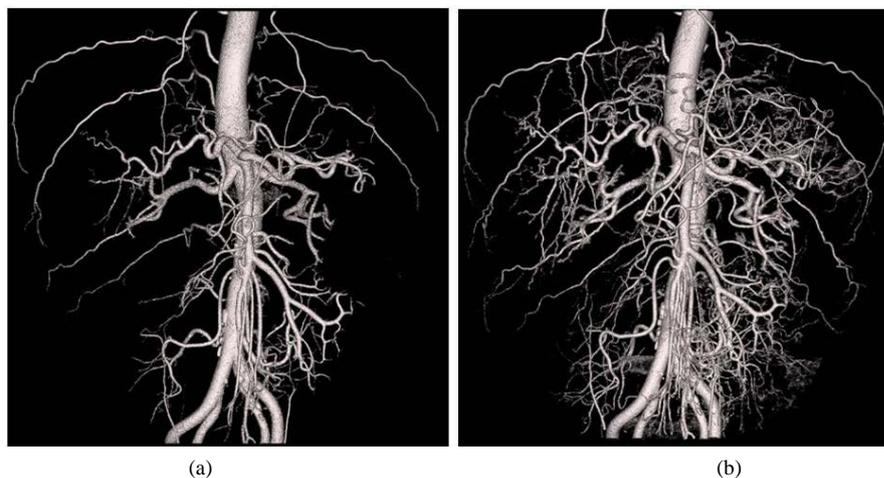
A 57-year-old woman with intraductal papillary mucinous neoplasm (IPMN). Two CT examinations were performed on follow-up every three months. The first was a standard CT scan (large focal spot, 120 kVp, FBP reconstruction), and the second a high-quality CT protocol scan. (a) CT arteriography from standard CT protocol; and (b) CT arteriography from the high-quality CT protocol using same opacity curve. High-quality CT arteriography (b) clearly shows the small subsegmental hepatic arteries of the liver and other small abdominal viscera artery branches. Visibility and sharpness of very small abdominal arteries were improved with high-quality CT arteriography.
